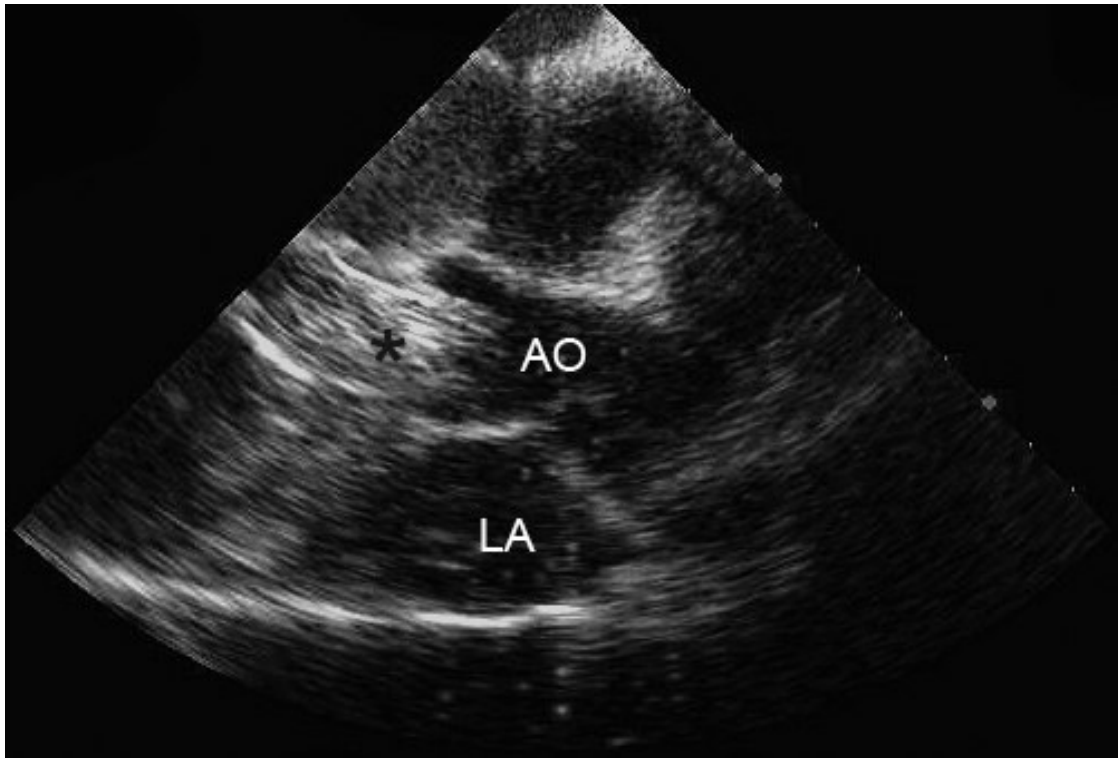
Inflation of the balloon across the aortic valve imaged with intracardiac echocardiography. The asterisk indicates the Inoue balloon. Ao: Aorta; LA; Left atrium.
